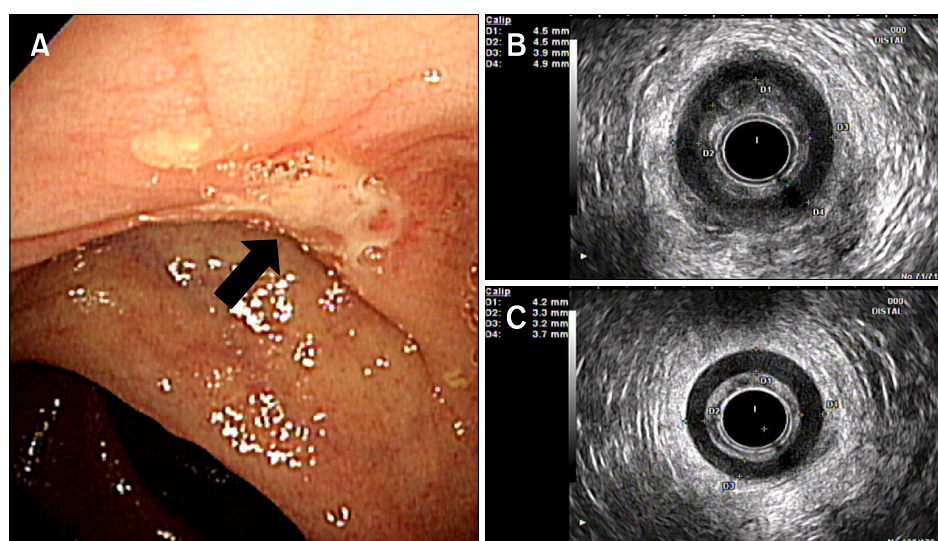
Endoscopic and sonographic findings of a 59-year-old woman with solitary rectal ulcer syndrome. (A) Sigmoidoscopy shows large ulcer with fold convergence (black arrow) in the lower rectum. (B) Increased thickness of internal anal sphincter is noted at mid level of anal canal. (C) Internal anal sphincter is also more thickened at low level of anal canal.
